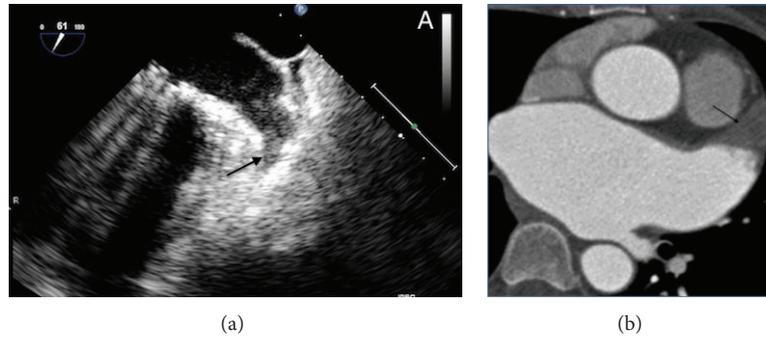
Left atrial appendage thrombosis (arrow), as seen with transesophageal echocardiography (a) and CT scan (b).
